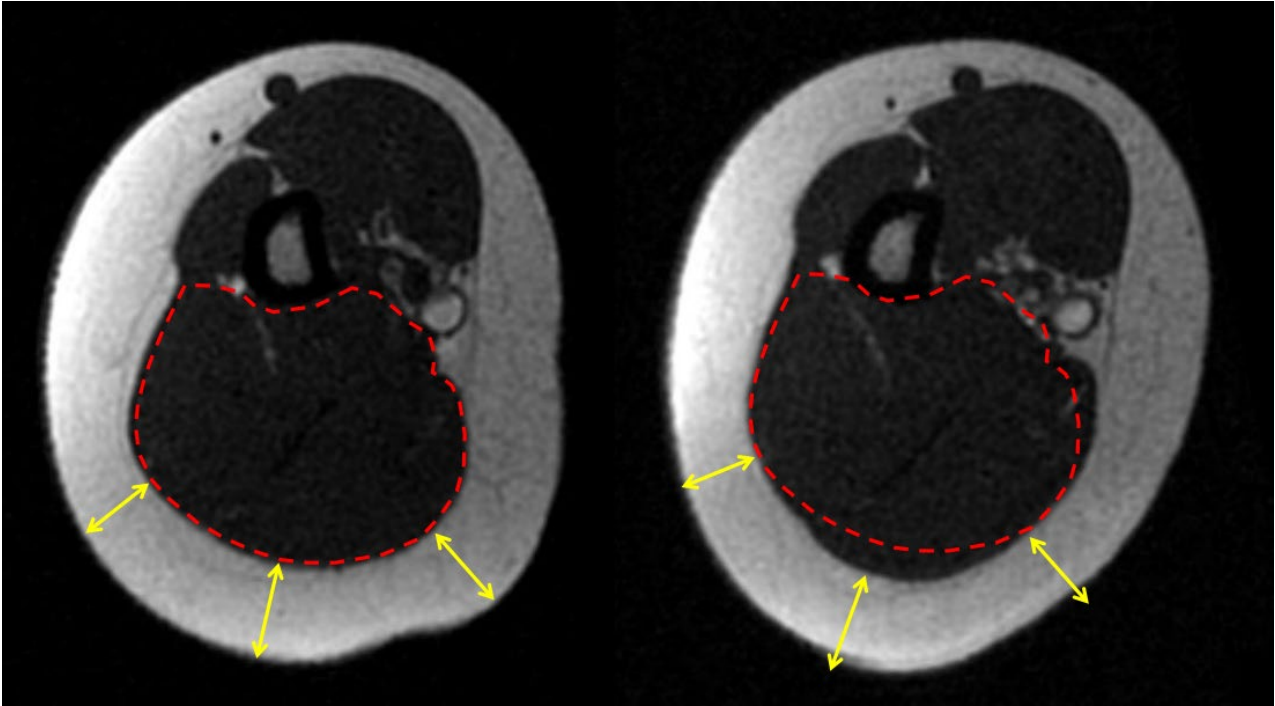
MRI scan showing difference in triceps muscle (red outlined area) and subcutaneous fat layer (yellow arrows) before (left) and 3 months after (right) treatment. The muscle increased in volume noticeably whereas the fat layer thickness reduced.
